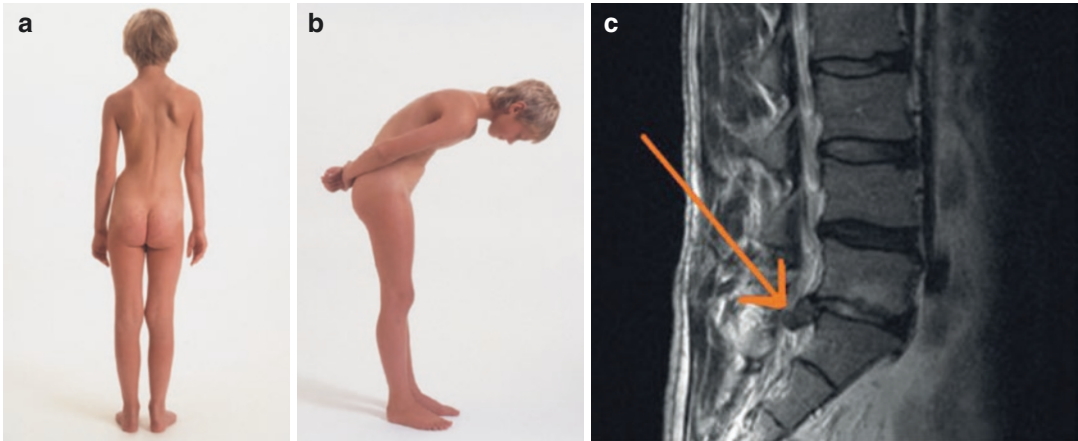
(a) Nine-year-old girl with painful scoliosis due to a hernia nucleus pulposus and (b) severely limited flexion of the thora-columbar spine. (c) MRI: disc herniation L5-S1
